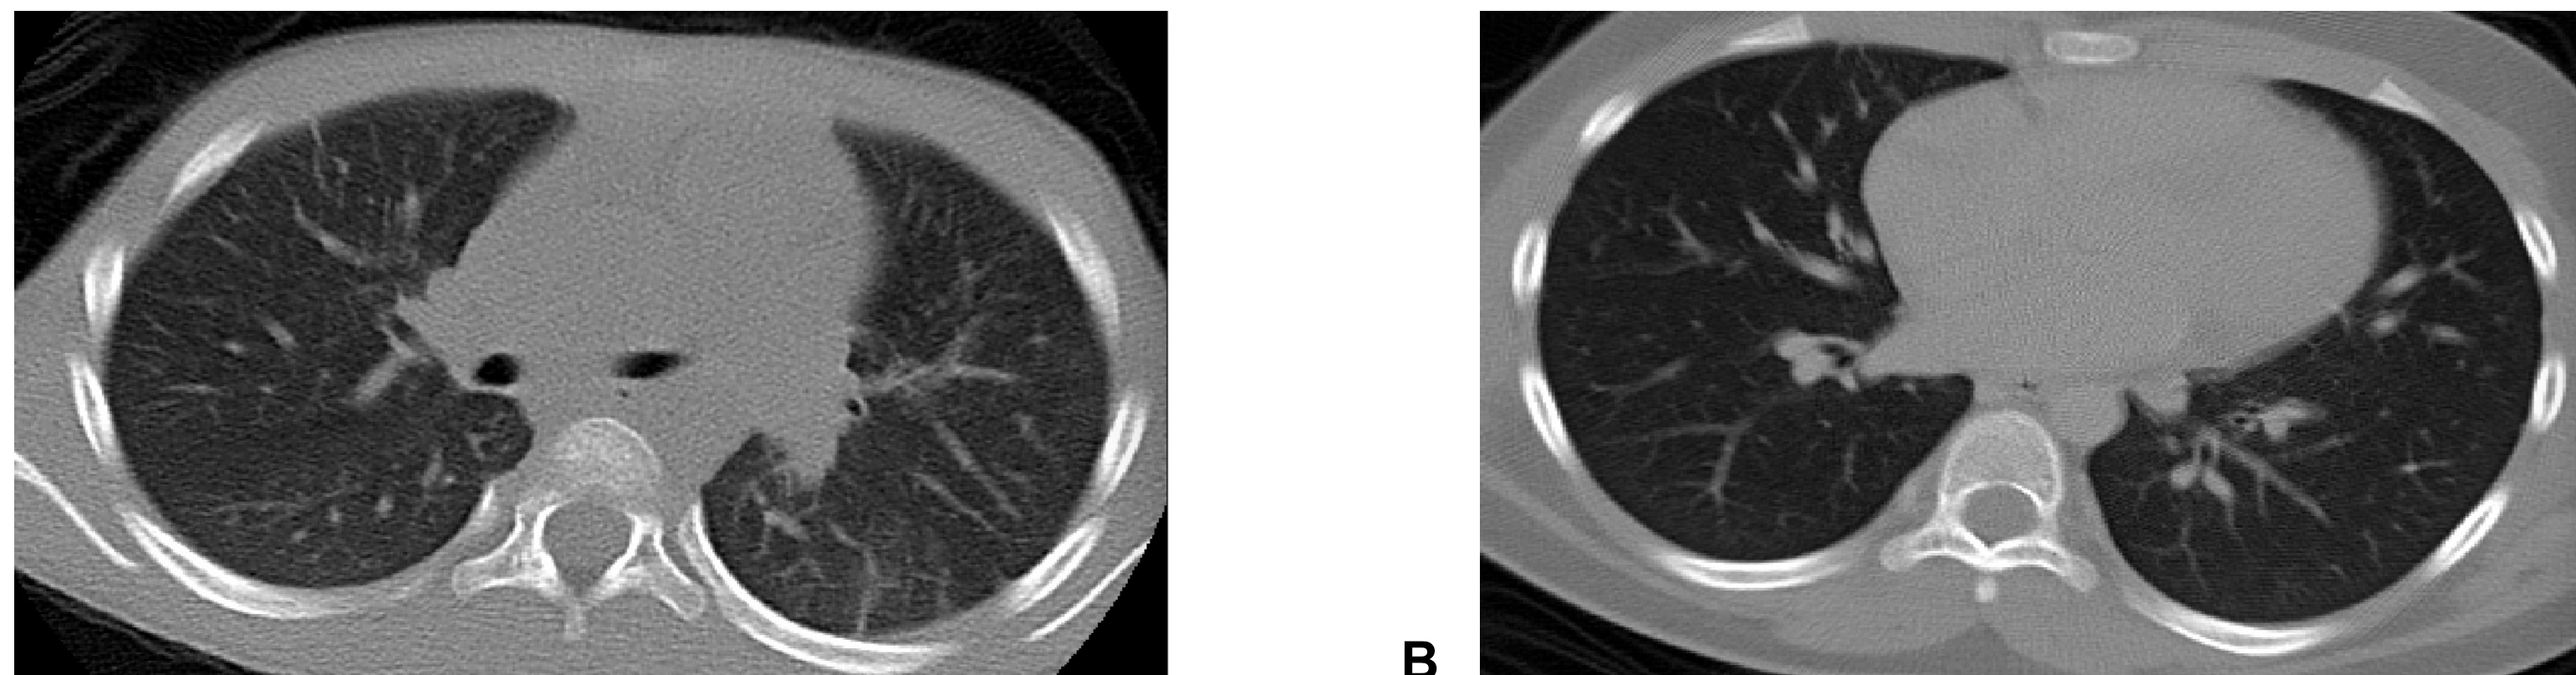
Representative changes in pediatric lung CT appearance with age. [Left] shows a CT chest image of a 5-year old prematurely-born child. [Right] The same child's lung CT scan at 9 years of age, displaying lung and body growth over time.
